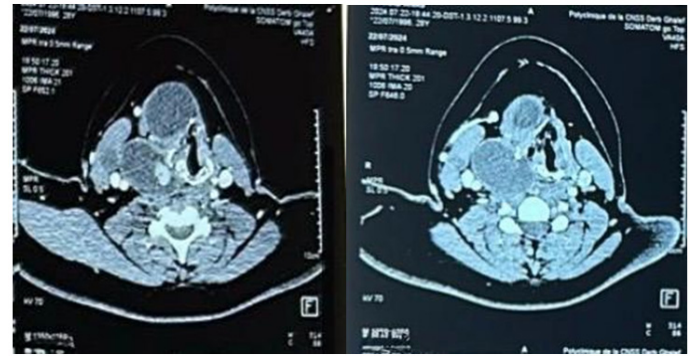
Axial contrast-enhanced CT scan showing a large lobulated right laterocervical mass with mixed cystic and solid components and calcifications, displacing the aerodigestive axis toward the contralateral side.
